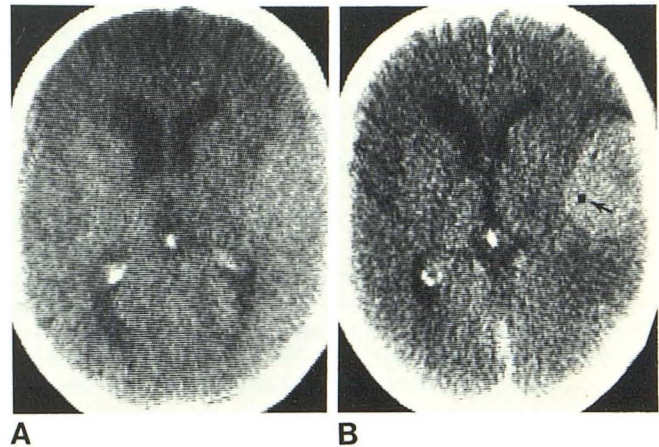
Case 9. A, Large left temporal lobe mass is slightly dense on nonenhanced CT scan. B, Scan with contrast material shows sharp borders and homogeneous enhancement. Square (arrow) denotes area sampled to determine μ and Z. Left carotid angiography (not shown) demonstrated diffuse tumor blush that persisted through venous phase. Preoperative diagnosis was meningioma.
